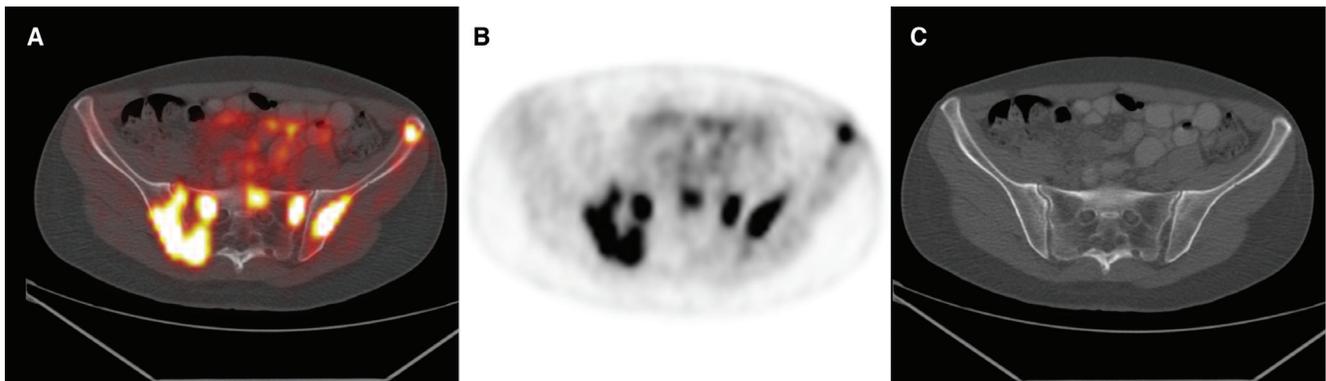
Transaxial (A) PET/CT fusion, (B) PET, and (C) CT images revealed extensive bone involvement of the skull base, right clavicle, spine, multiple ribs, sternum, proximal left humerus, right femur and extensively throughout the pelvis with maximum standardized uptake value (SUV_{max}) 8.3.
